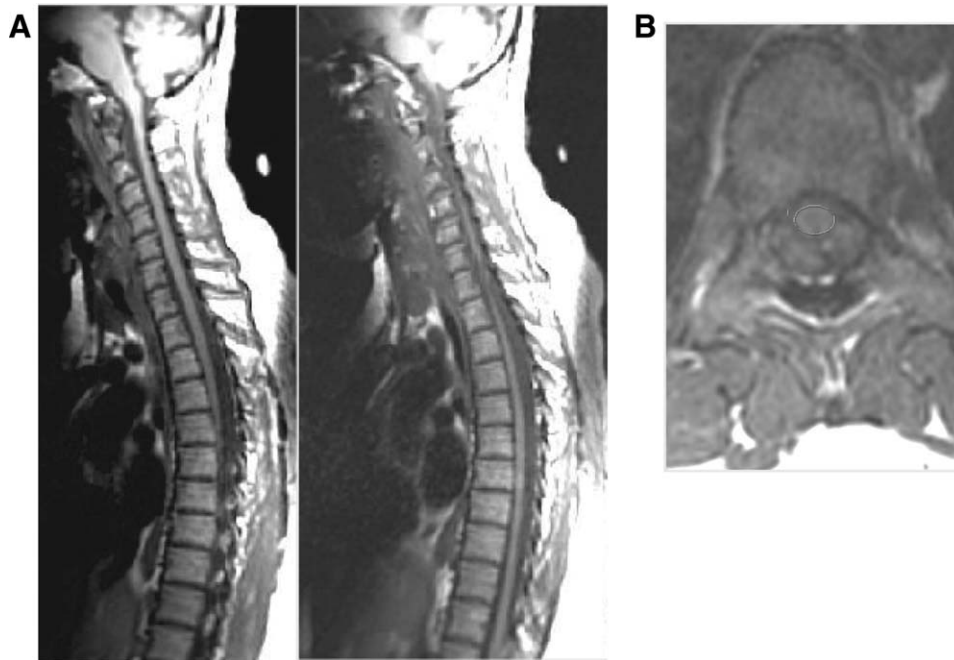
MRI of brain and spinal cord in NTE-NMD syndrome. (A) No significant intracranial abnormality is identified. The corpus callosum (not shown here) was present without evidence of atrophy. Significant spinal cord atrophy is present beginning at the T3–4 level where the cord again expands at the conus medullaris. Although atrophic, the spinal cord was not compressed, and there were no spinal cord aberrations. (B) Cord transverse area (circle) at T9 measured 25 mm^2 at the T9 level (compared with control subjects, not shown) that measure $39.3 \pm 8.1 \text{ mm}^2$.
